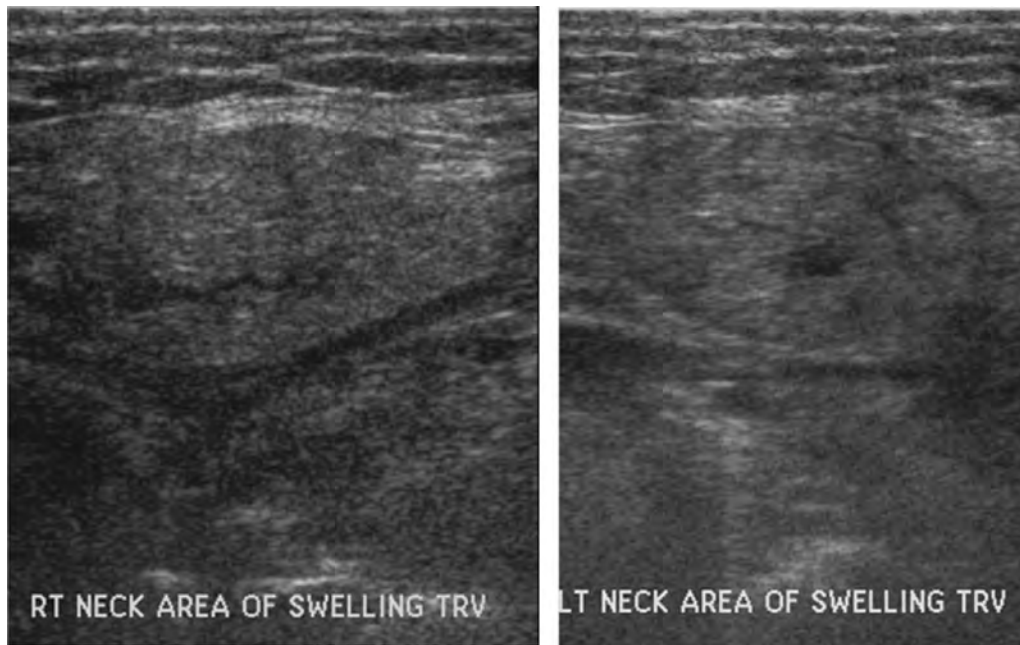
72-year-old male with impaired renal function who developed bilateral submandibular swelling 12 hours after administration of 140 mL of Isovue 250. Ultrasound images of the submandibular glands showing diffuse gland edema and enlargement.
